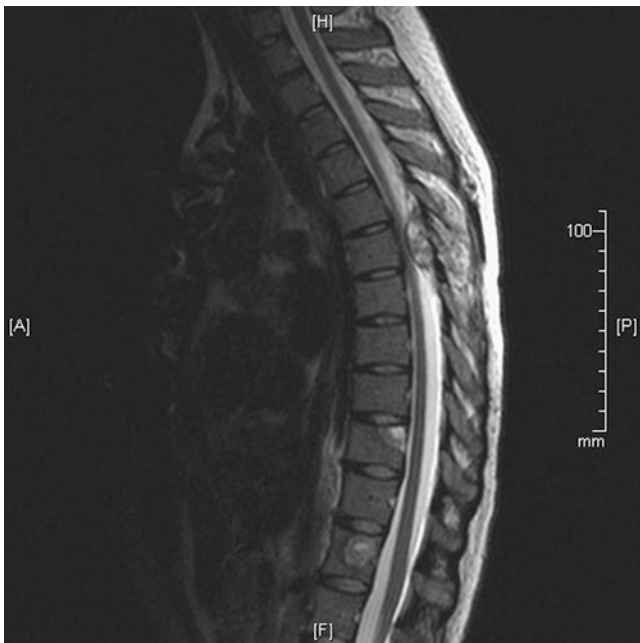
T1 weighted MRI images of metastatic cardiac angiosarcoma with spinal metastases and invasion into the spinal canal
